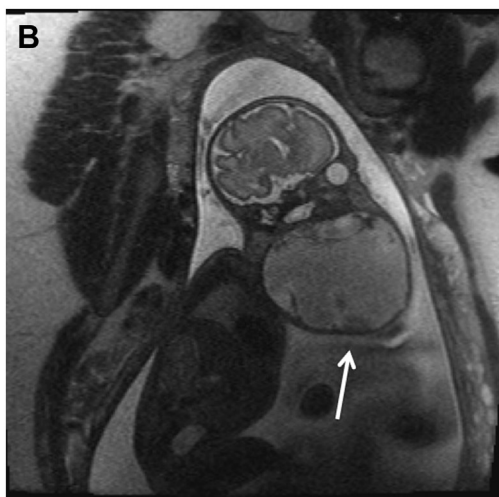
Ultra-fast prenatal magnetic resonance imaging. (A) Twin pregnancy with one fetus with a cervical teratoma (black arrow). (B) Giant cervical teratoma (white arrow) in a fetus with cystic and solid components. Reprinted with permission from Lioy J, Sobol S editors. *Disorders of the neonatal airway: fundamentals for practice*, p. 182. © Springer, 2015.
